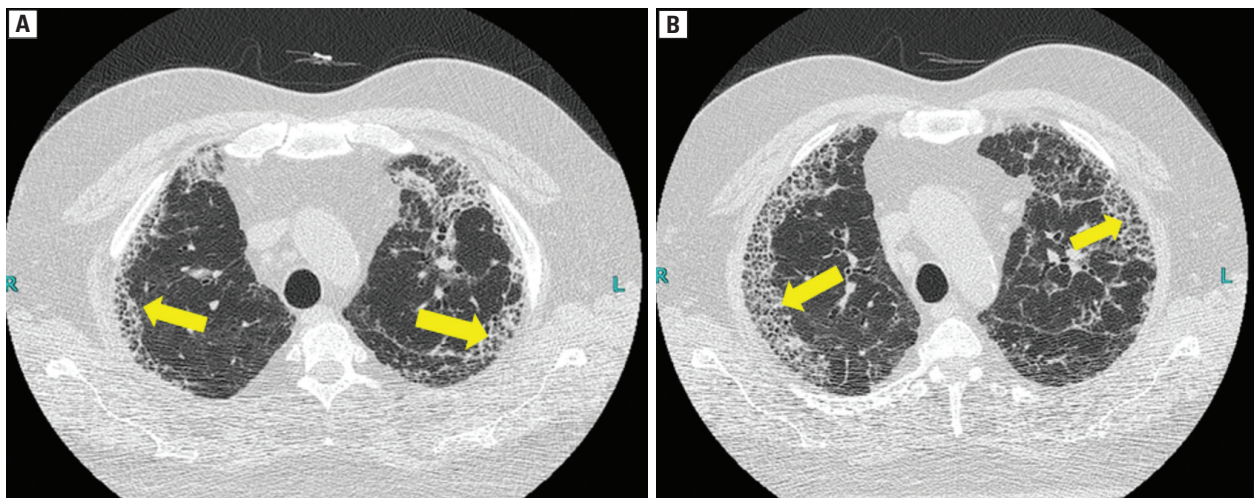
HRCT of the chest showing A. honeycombing and reticulation (yellow arrow showing honeycombing); and B. persistent and worsening of honeycomb fibrosis (yellow arrow showing honeycombing)
